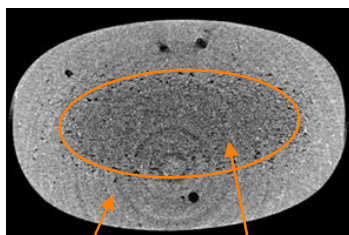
Tomogram (3D imaging reconstructed) of the entire HPMC ER4H tablet after 45 min dissolution in HCl using X-Ray micro Computed Tomography.
